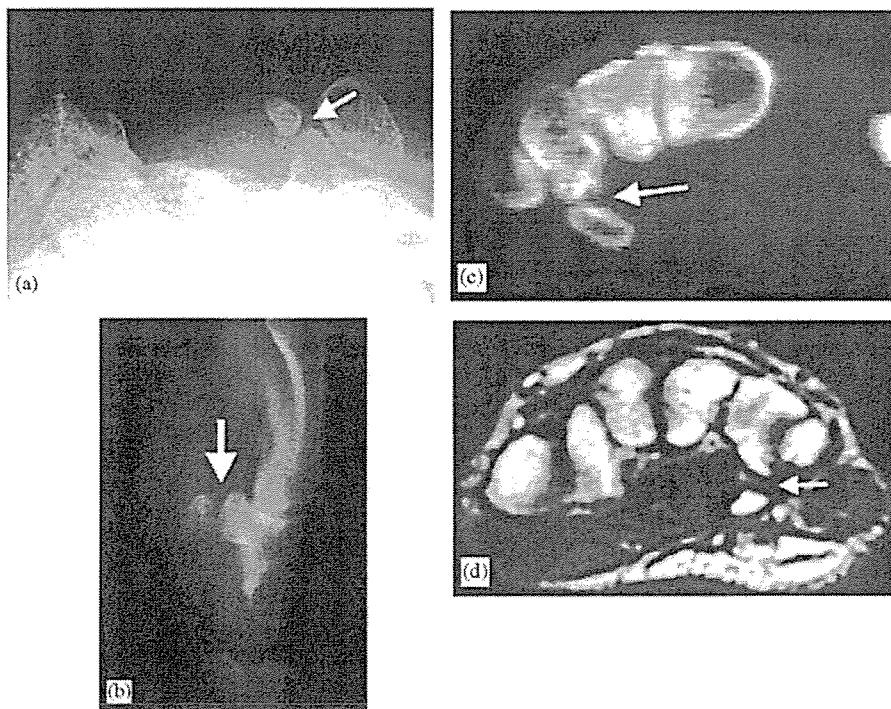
Non-union of the middle part of the hook of the hamate bone: (a) on carpal tunnel view X-ray (case 3), (b) on tomography (case 5), (c) on CT scan (case 1) and (d) on MRI (case 6).
